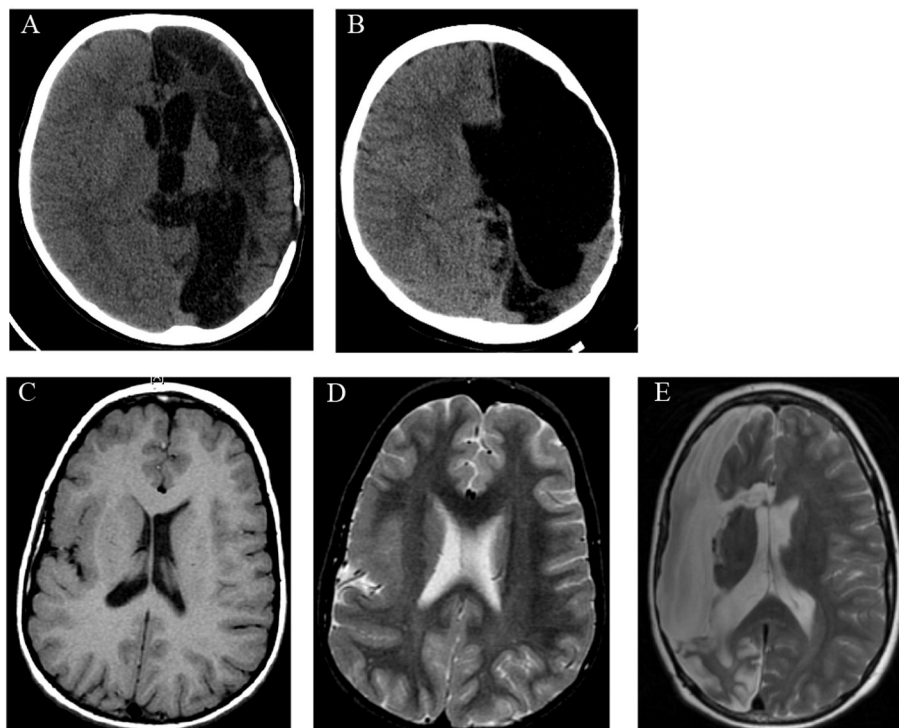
(A, B) Non-contrast CT brain from the patient described in the first case both before (A) and after (B) hemispherectomy. (C–E) T1 and T2 non-contrast MRI brain from the patient described in the second case before (C, D) and T2 non-contrast MRI brain after (E) hemispherectomy with incomplete disconnection posteriorly.
